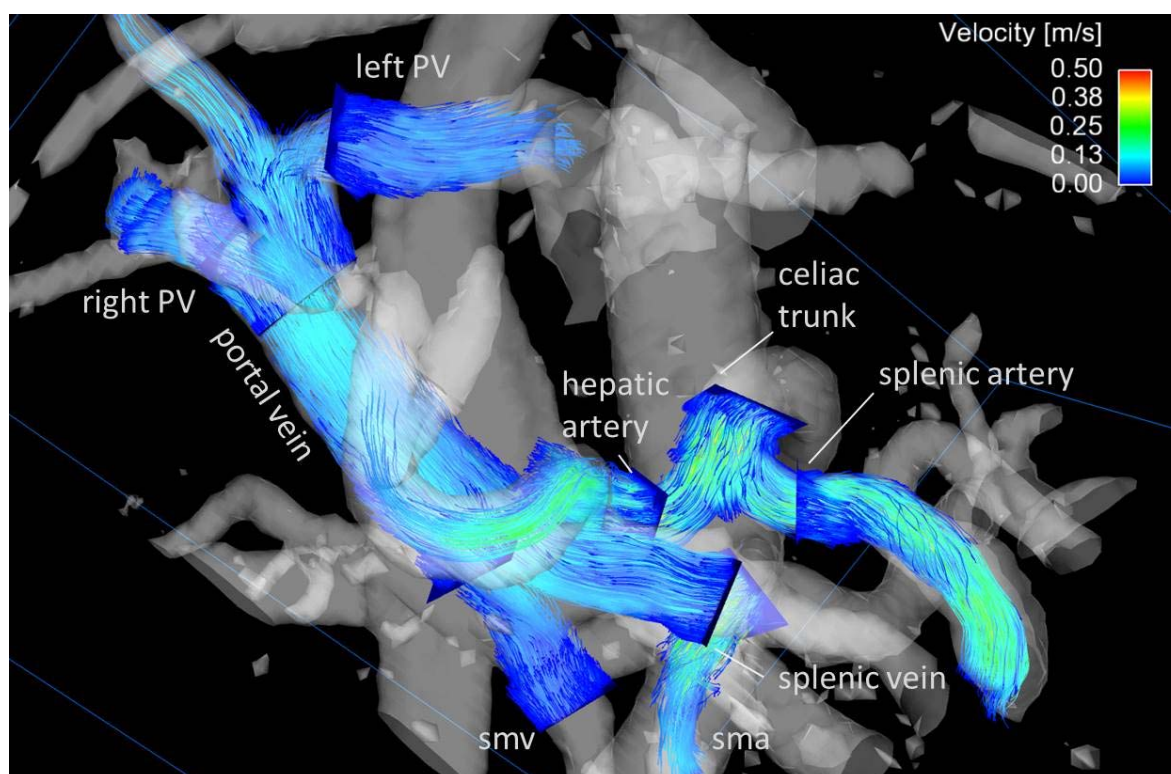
4D flow MRI visualization with particle traces from emitter planes in the superior mesenteric and splenic vein, proximal and distal splenic-mesenteric confluence, right and left intrahepatic portal vein branch, celiac trunk, splenic, mesenteric and hepatic arteries. A regular physiological hepatic blood flow is shown in the arterial and portal venous systems.
